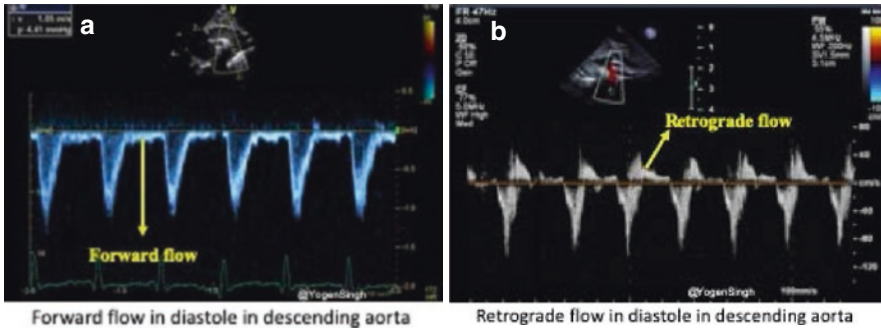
Pulsed Wave Doppler assessment of blood flow in descending aorta (Post-ductal flow). (a) Forward blood flow during diastole and (b) Retrograde blood flow during
